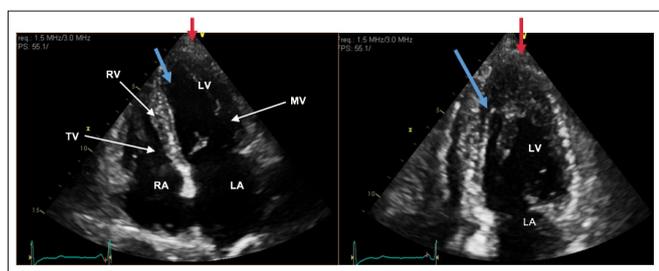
Apical four chamber (left) and apical two chamber (right) echo views demonstrating septal (blue arrows) and apical hypertrophy (red arrows). Concentric Left Ventricular hypertrophy is a key feature in AFD. A subset of patients have an asymmetrical variant with septal thickening (as above) and posterior wall fibrotic thinning. (1,2)
